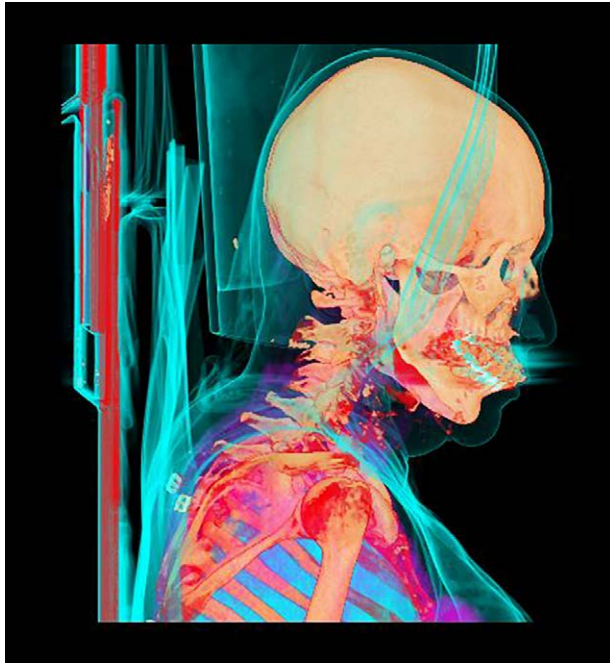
The computed tomography scan of the 64-year-old patient reveals a high hyoid bone. All soft tissues are located supraplatysmal, and there is a noted ptosis of the submandibular gland. The patient exhibits fine wrinkled skin and age-related changes such as hyper elastosis, along with signs of photoaging and chronological aging. In both frontal and side views, pronounced marionette lines are evident. The proportions of all 3 facial segments are balanced, with sagging skin presenting an obtuse angle. The chin projection is adequate, and there is a presence of supraplatysmal fat.
